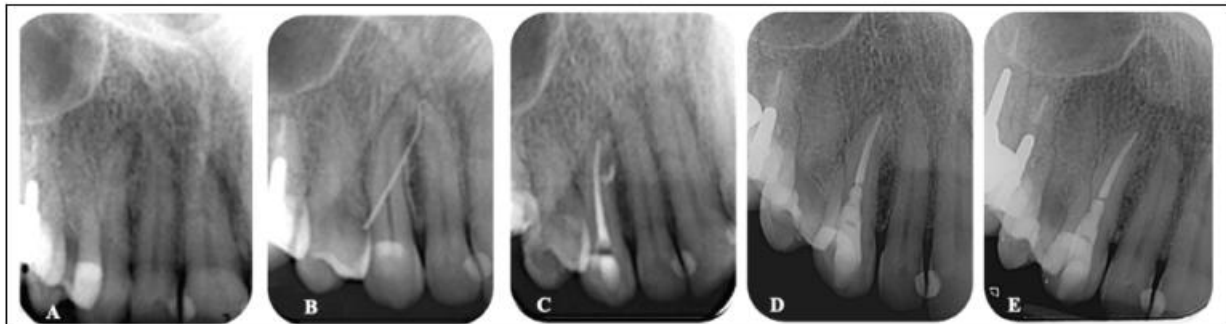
A/ The initial radiograph on tooth #13-PAI5; B/ preoperative radiograph with gutta-percha through the sinus tract; C/ Control radiograph after the root canal obturation-a lateral canal was sealed; D/ 4 years follow-up-PAI1; E/ 7 years follow-up-PAI1.
